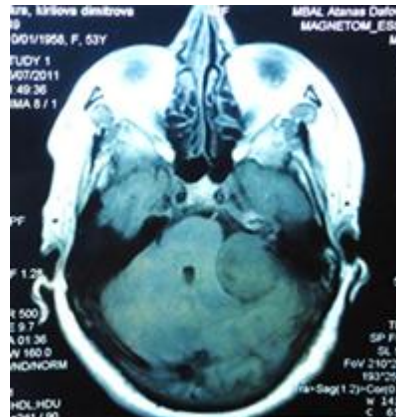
MRI image of acoustic neuroma
